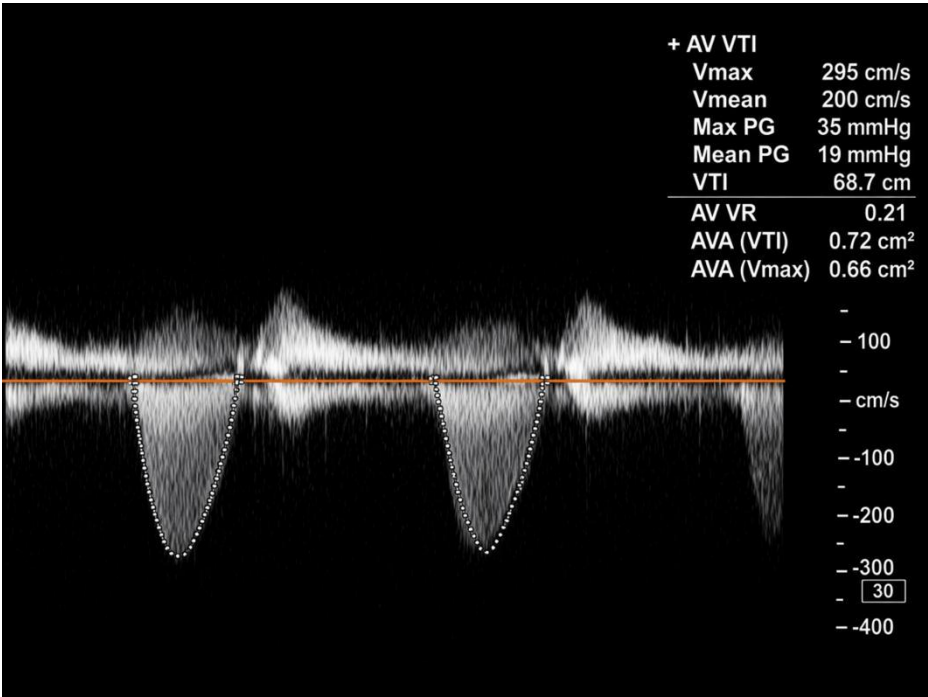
Continuous-wave Doppler across the aortic valve (AV VTI).
